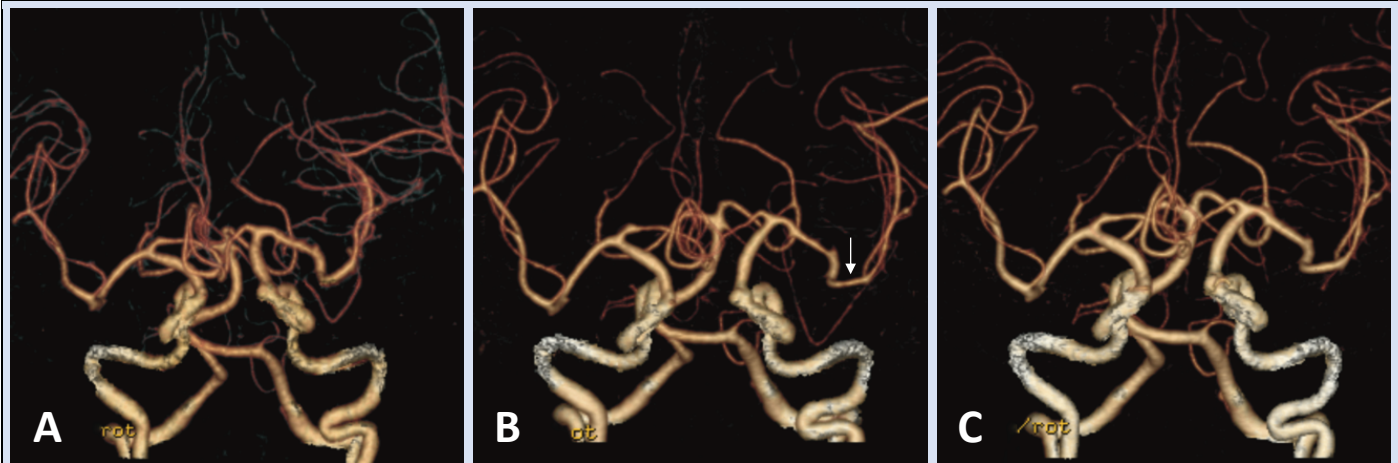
3D CT angiography findings A. Initial angiography on day 0 showing no vasospasm; B. The arrow points at the vasospasm site on day 5; C. The vasospasm is relieved completely on day 9.
